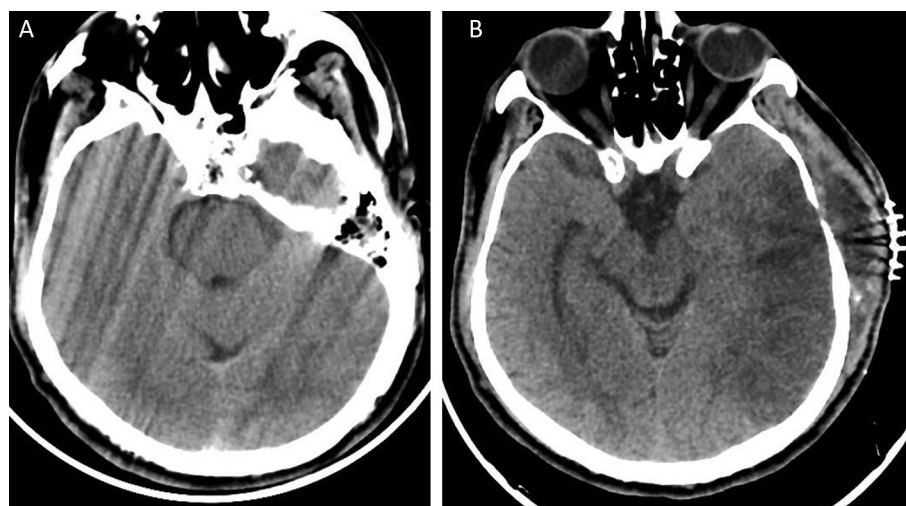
A: The latest pre-operative cranial CT scan, which shows the compression of the basal cisterns. B: The early post-operative cranial CT scan, which shows that the basal cisterns were decompressed.
